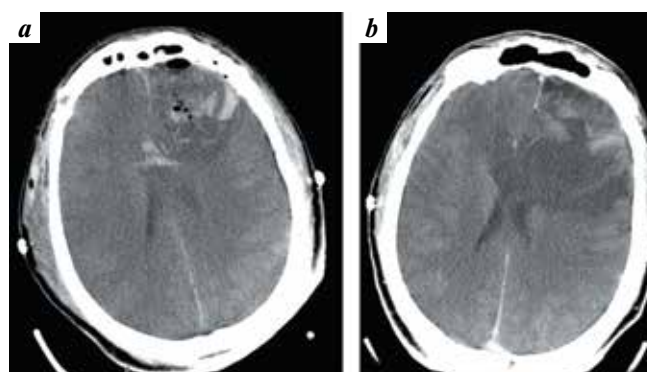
Computed tomography of patient G. (axial projection): a – 12 hours after the surgery; b – 12 days after the surgery: increased area of edema and ischemia in the left frontal lobe
